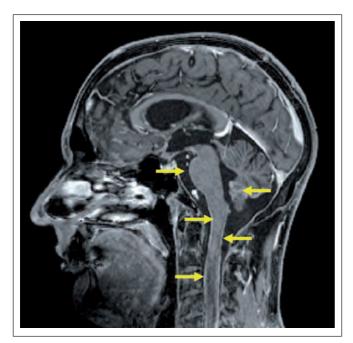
T1-weighted MRI (sagittal) with contrast media, showing enhancement of the meninges (arrows).
